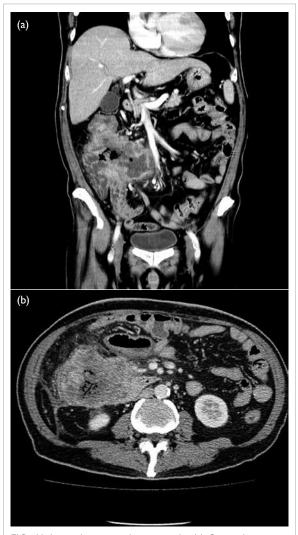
Abdominal computed tomography. (a) Coronal view showing a large colonic tumour arising from the ascending colon and (b) axial view showing the colonic tumour with invasion of the right perirenal fascia
